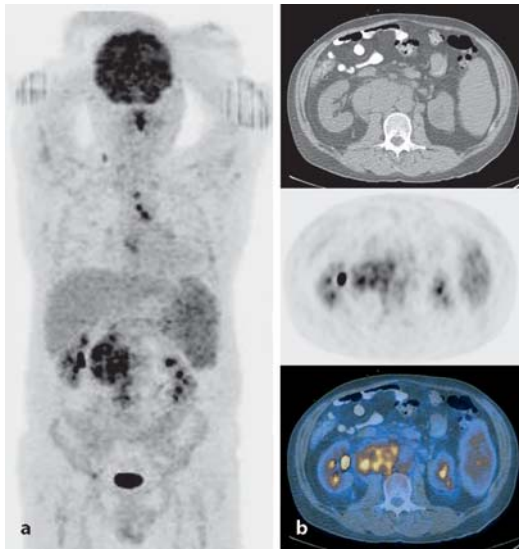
a, b. A 60-year-old male patient with a Hodgkin's disease stage III. FDG-PET/CT reveals increased FDG-uptake in the spleen (a), retroperitoneal lymph nodes (b) with clearly enlarged lymph nodes
